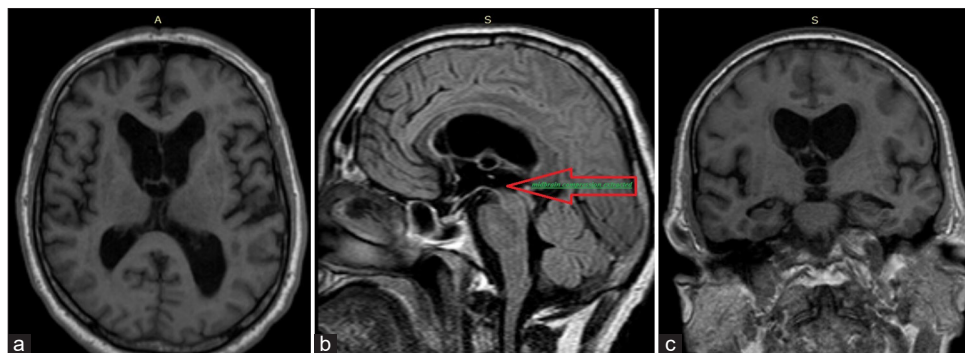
The brain magnetic resonance imaging (MRI) taken 3 months after the operation. (a) MRI T1 axial. (b) MRI flair sagittal. (c) MRI coronal. (b) The red arrow shows that midbrain compression is extracted.
